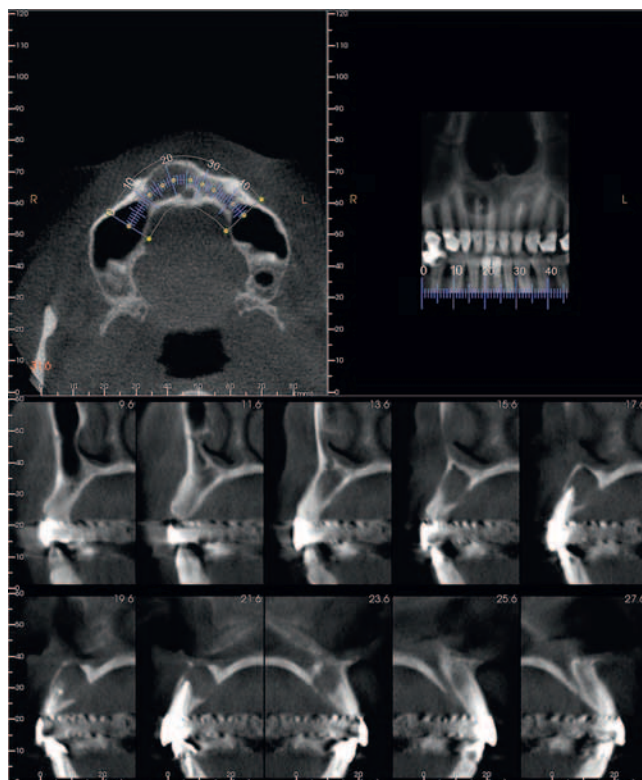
CBCT example: These series of images show an ovoid radiolucent area in the anterior right maxilla. Both teeth 1.1 and 1.2 were endodontically treated; however, given the epicenter of the entity relative to the teeth, the radiolucent area was interpreted to be a keratocystic odontogenic tumour. (Courtesy Dr. E. Lam.)
